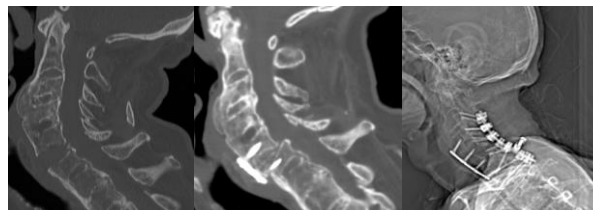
C. Intraoperative radiography and post-operative cervical CT reveal good alignment of the fracture.
